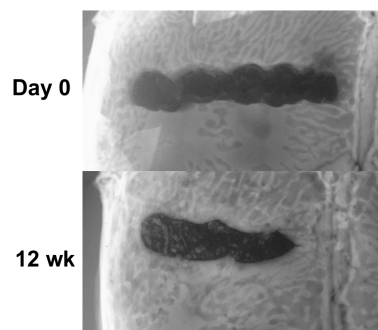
Radiographs of calvaria after novel interfrontal suturectomy surgery
